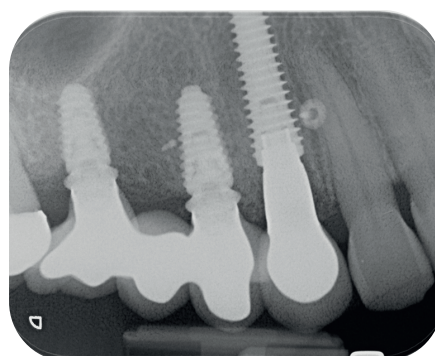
Radiograph following restoration with definitive crown
